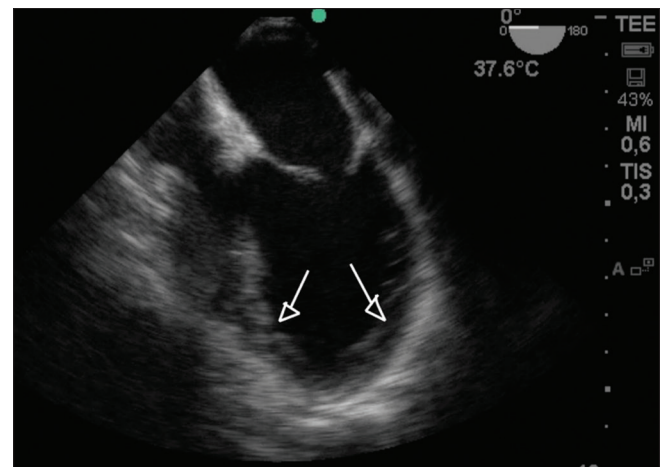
Mid-esophageal, four chambers view transesophageal echocardiography. Arrows showing left ventricular dilatation
